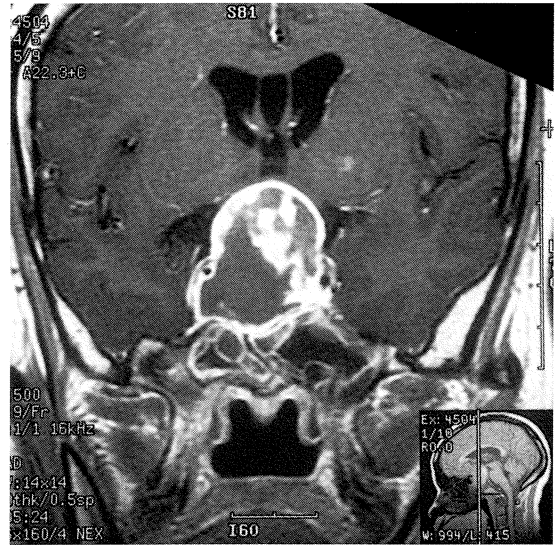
Coronal post-Gd-DTPA SE T1-W MR image of the brain, at the corresponding level to figure 2a.
